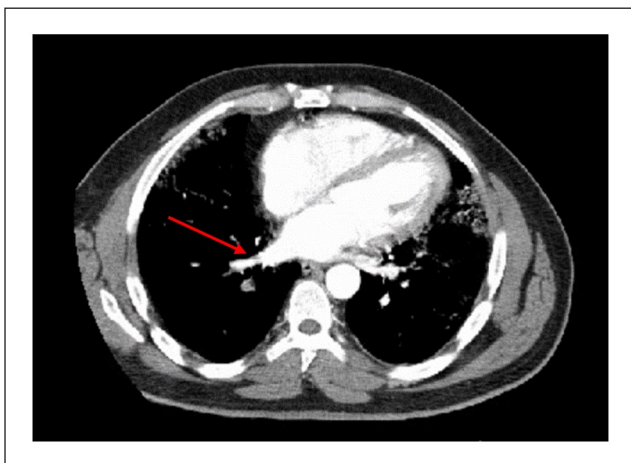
CT pulmonary angiogram showing a right lower lobe pulmonary arterial thrombus. (Arrow marks the thrombus).
